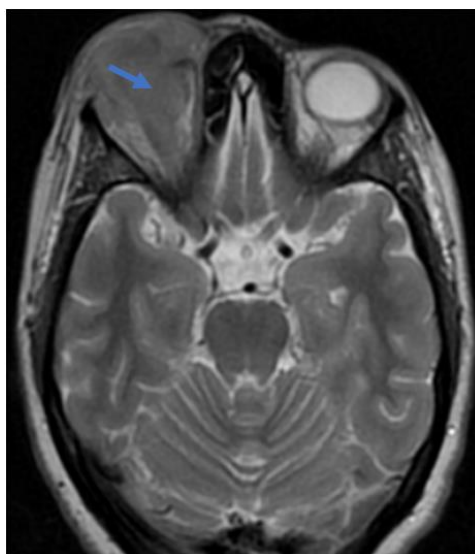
Axial T2-weighted MRI showing a heterogeneous hyperintense right orbital mass (blue arrow)
